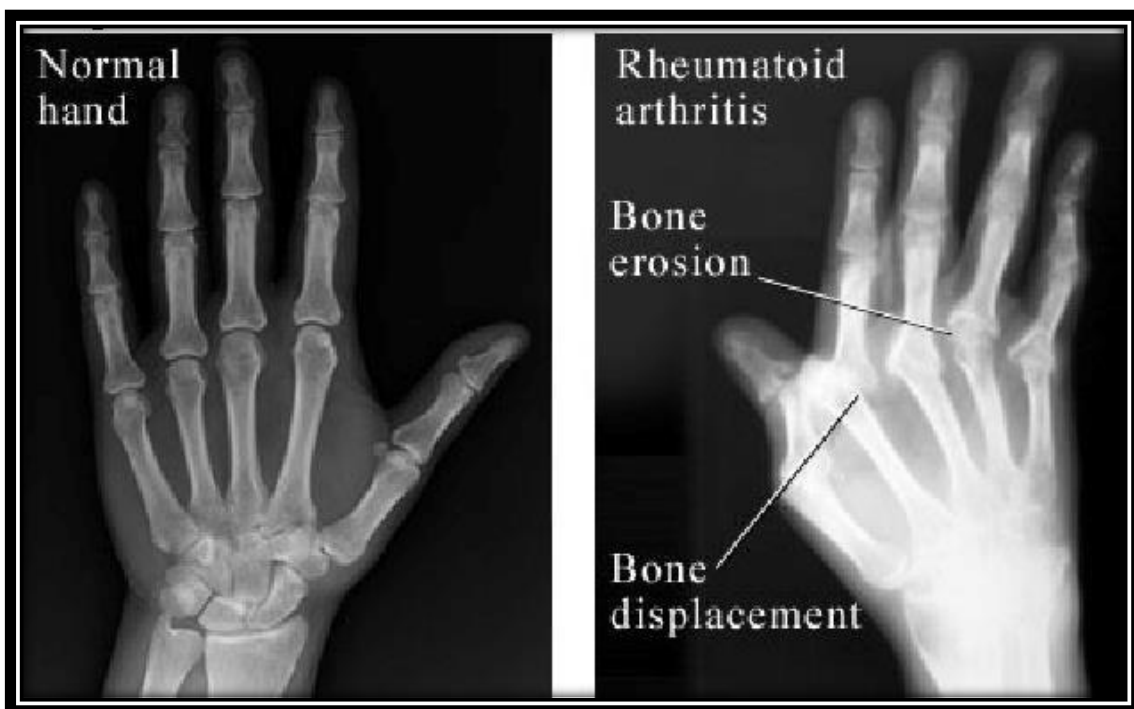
X-Ray changes seen in hand with RA⁽¹⁰⁾
